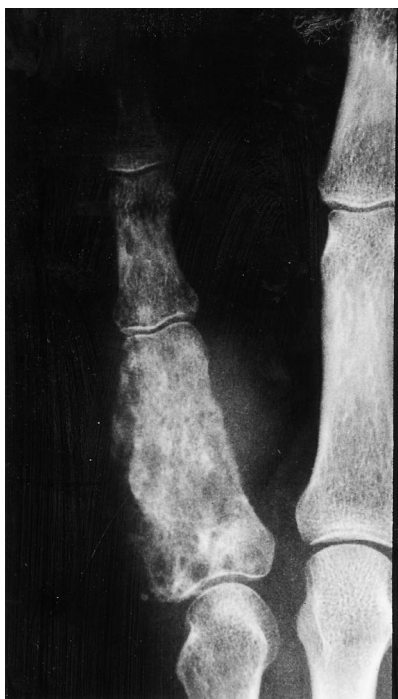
Plain radiograph of the little finger showing a locally aggressive lytic lesion with disruption of the cortex and a soft tissue swelling.
